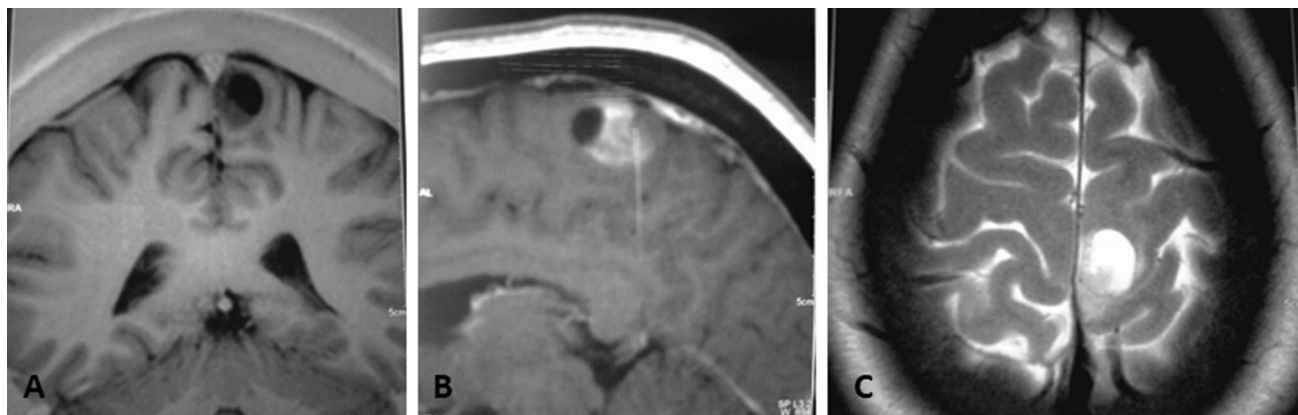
MRI scan images of the patient in November 2012. a T1; b T1-gadolinium; c T2
